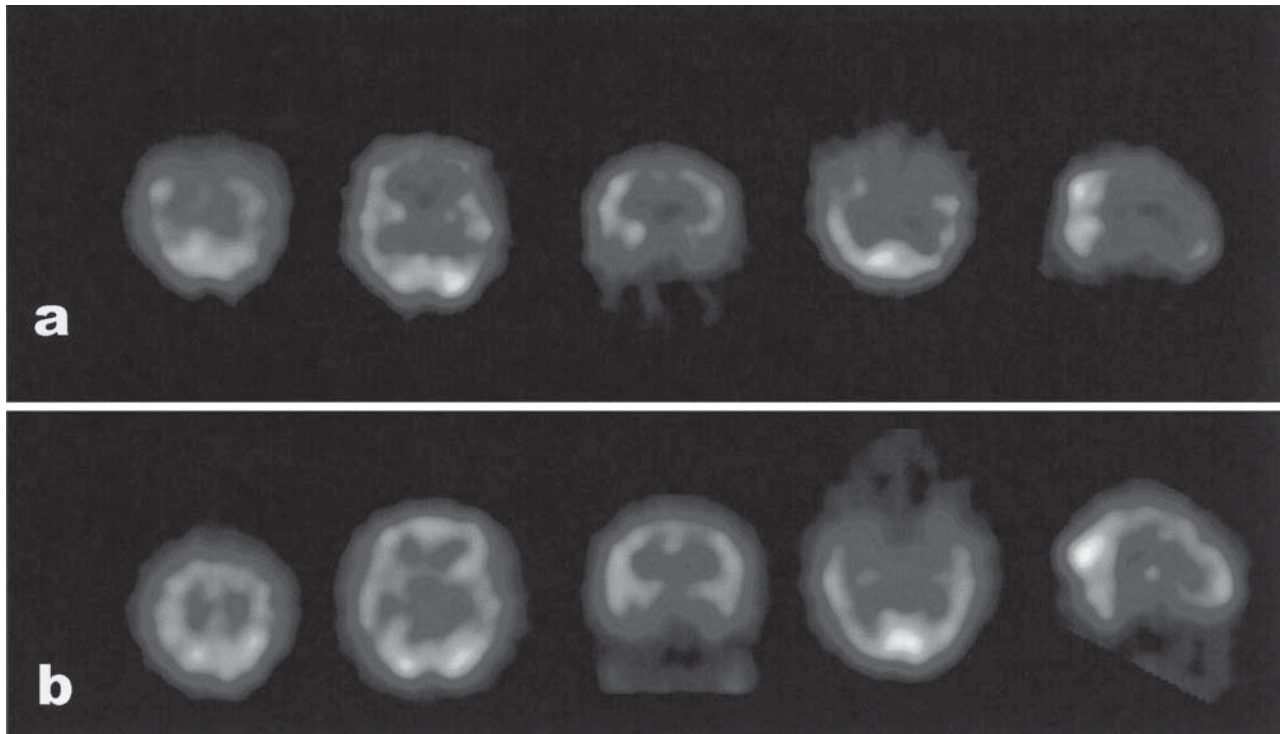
Brain SPECT of patients with MCI. (a) Patient who deteriorated to PMCI (hypoperfusion in the prefrontal, parietal and temporal lobes). (b) Patient who remained with SMCI (hypoperfusion in the temporal lobe)
